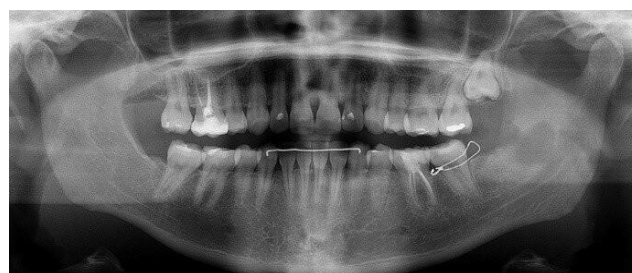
Initial radiographic image made in 2018 after clinic examination with visualization of a well-circumscribed radiolucent lesion in the angle and left mandibular ramus region.
